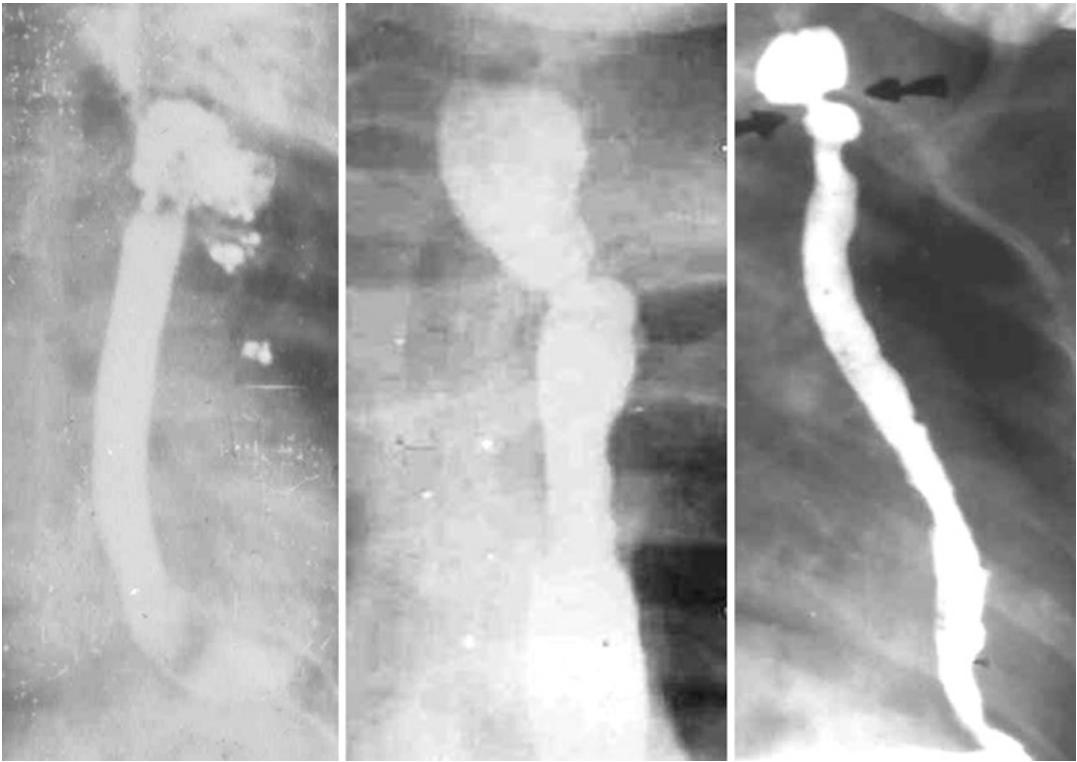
X-ray of common complications of cervical anastomosis: fistula, mild or severe stenosis
